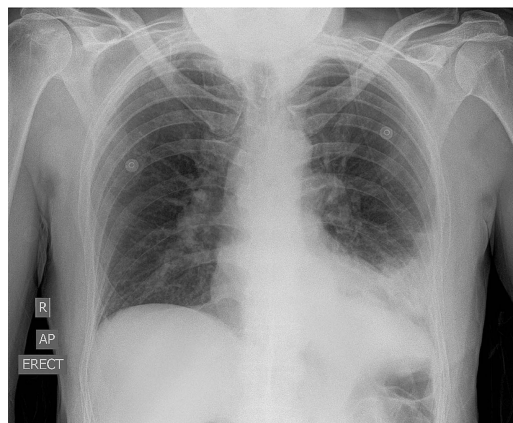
Chest X-ray: consolidation of the left lower lobe.
